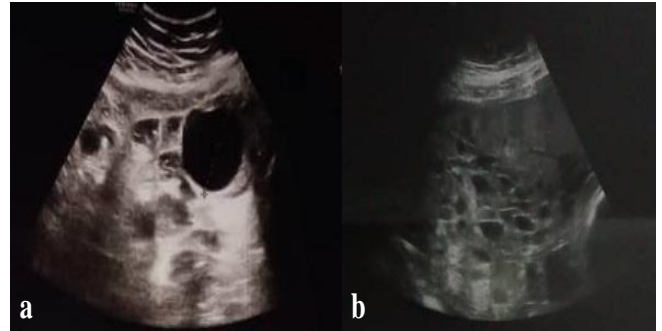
Ultrasound scans of the molar pregnancy at (a) 21st week and (b) 35th week of gestation
